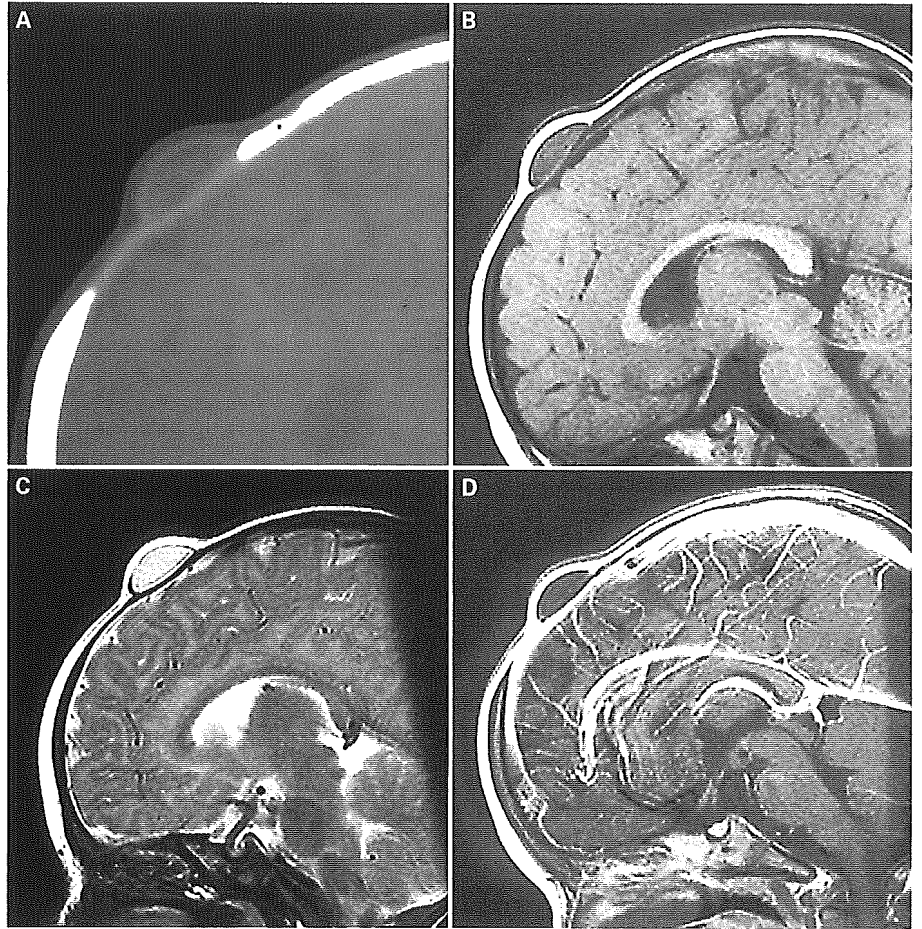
Case 2 at age 15 months. Coronal CT images demonstrating a mass lesion located on the posterior part of the anterior fontanelle (A). The lesion is a hypointense mass on a MR T₁-weighted image (B) and hyperintense on a T₂-weighted image (C); it is unconnected to the intracranial areas. No enhancement was seen with Gd-DTPA (D).
